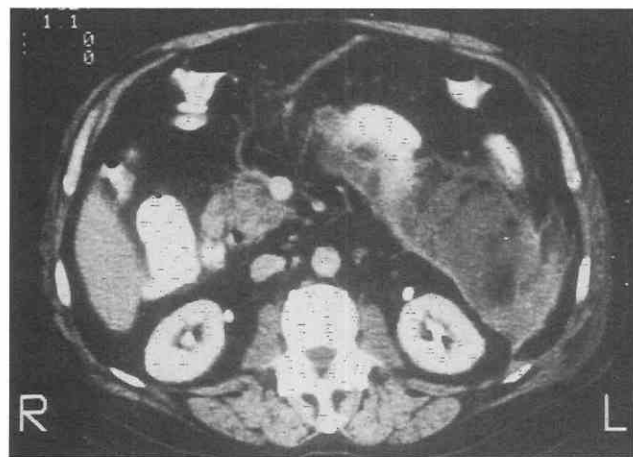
Fluid in the anterior pararenal space. Intravenous contrast-enhanced CT scan in a patient with acute pancreatitis demonstrates peripancreatic fluid in the left anterior pararenal space.
